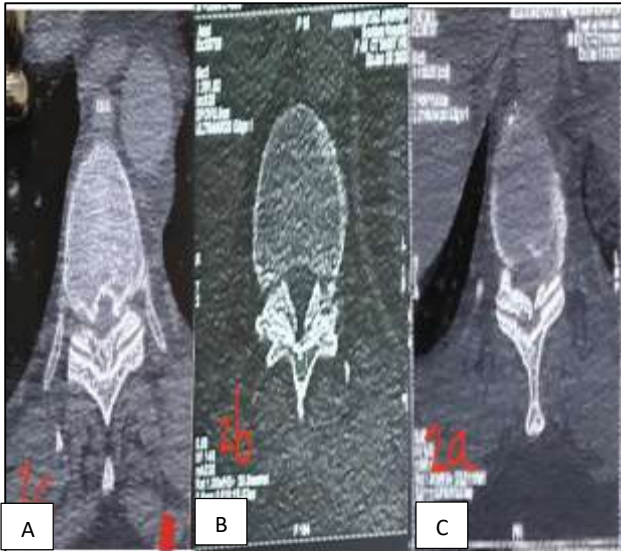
(A-C): Morphology of OYL on axial CT scans. Unilateral, bilateral and bridged.
